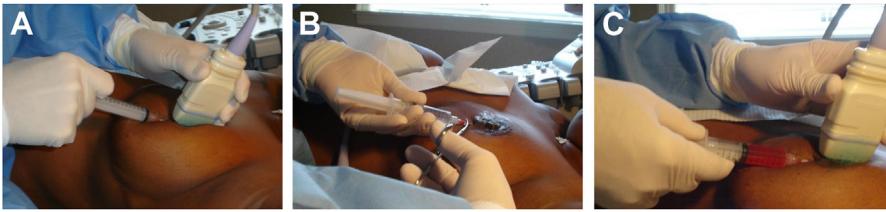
Ultrasound-guided aspiration of abscess. (A) Large bore needle is inserted into abscess cavity and the pus is aspirated. (B) Needle held in place with hemostat while pus-filled syringe is replaced with one filled with lidocaine. (C) After slowly distending cavity, the lidocaine is vigorously swished in and out to thoroughly irrigate the abscess cavity.
